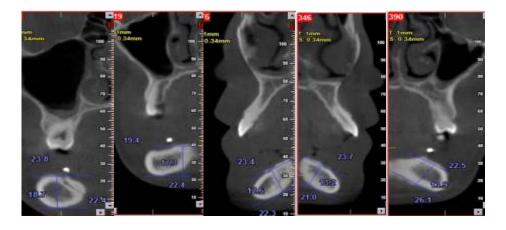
cone beam computed tomography before implant placement (after 10 years follow up)
